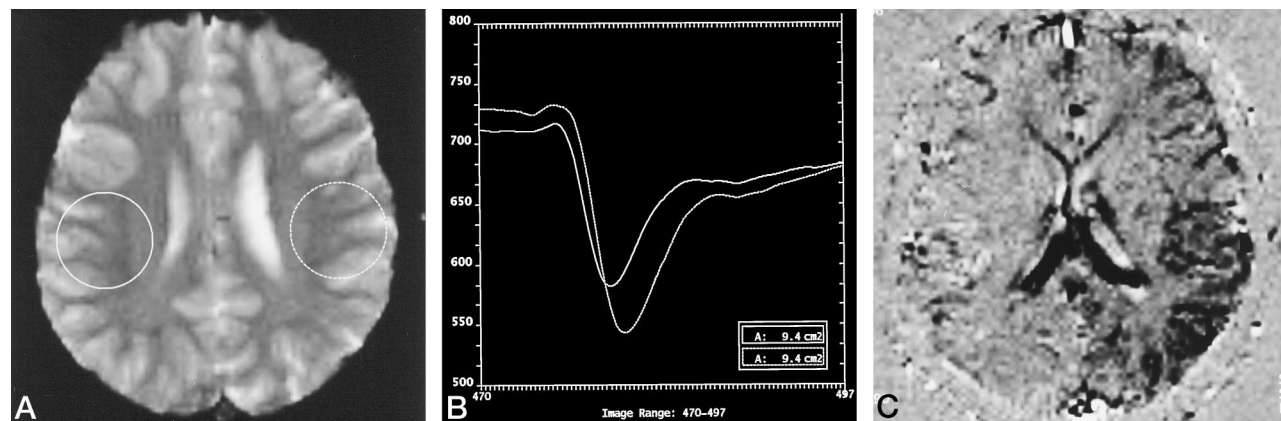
Case 4: 31-year-old woman with moyamoya disease predominantly affecting the left side. MR images showed a small infarction in the right frontal subcortex.
